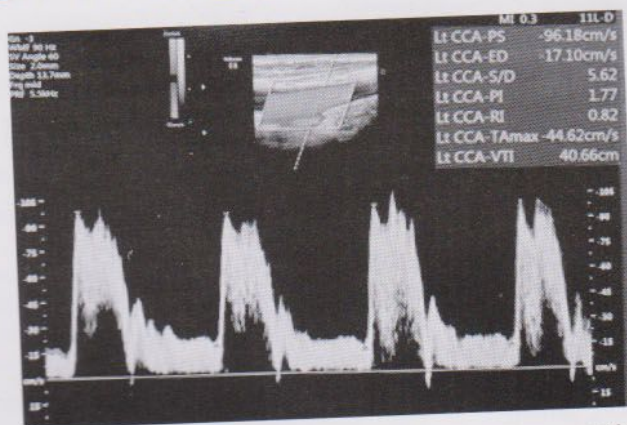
showing normal Left common carotid artery doppler waveform.
